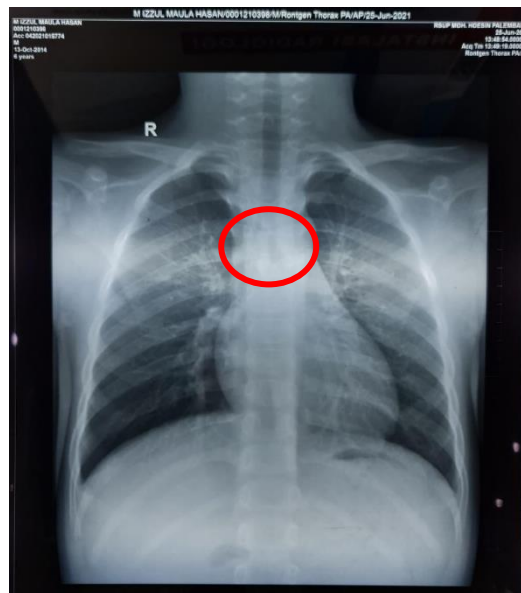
Thorax X-ray imaging before bronchoscopy procedure.
